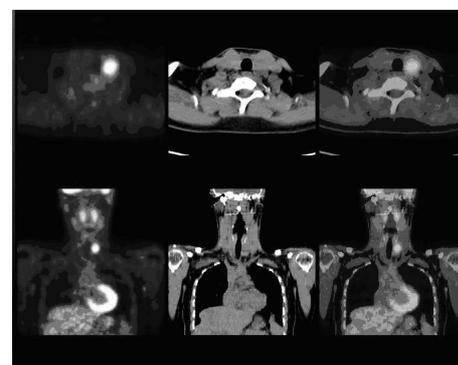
Papillary thyroid cancer incidentally identified by FDG PET imaging in a patient with a brain tumor.
